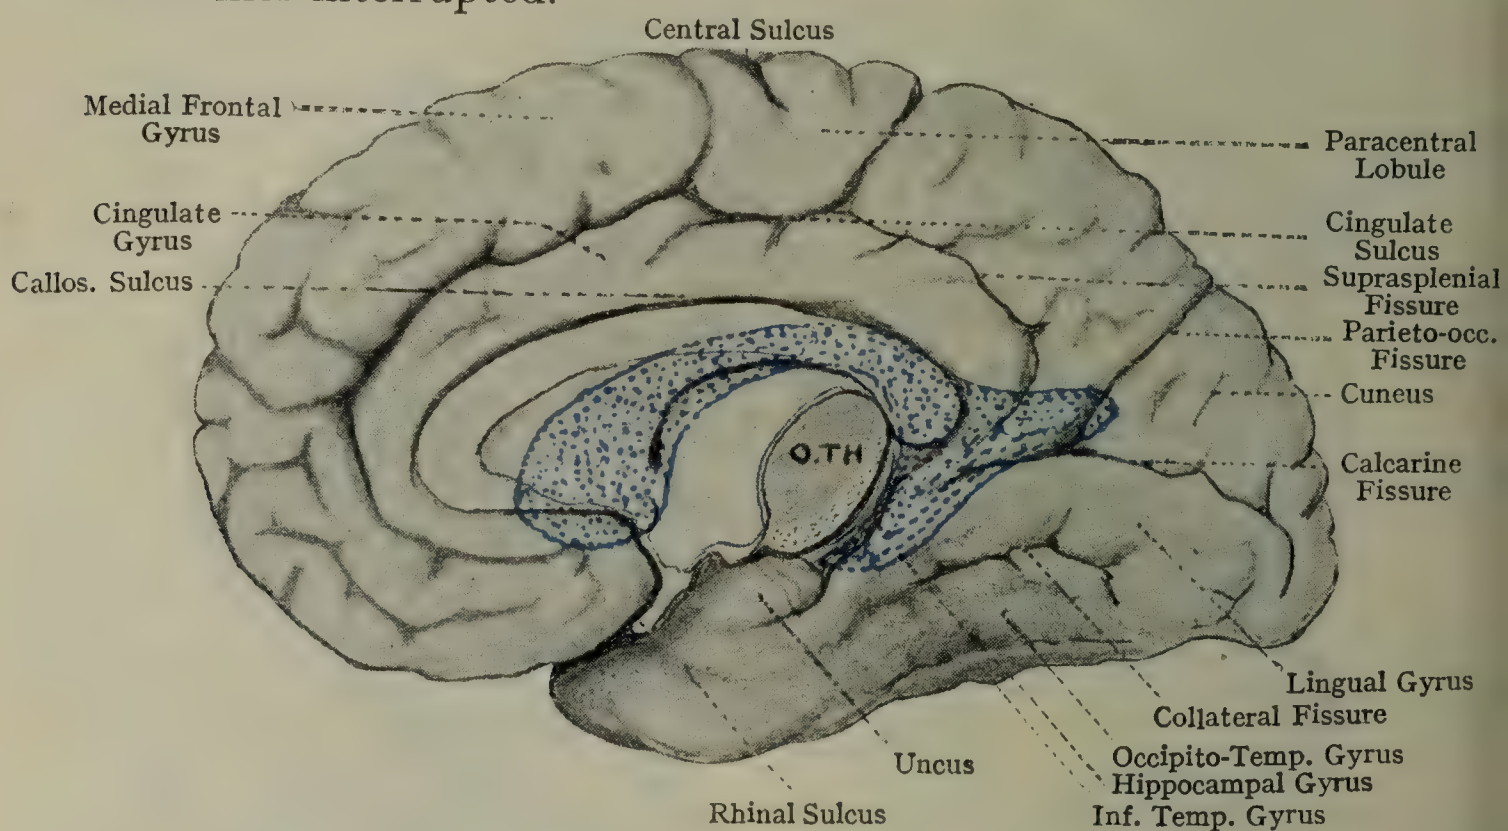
MEDIAL ASPECT OF RIGHT HEMISPHERE.
